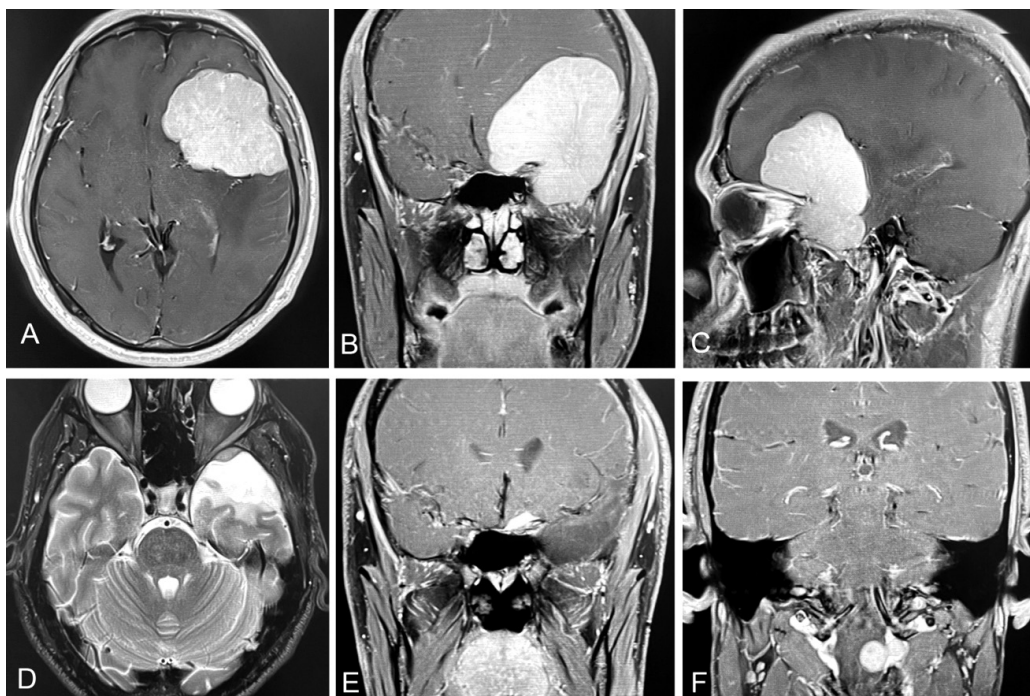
Preoperative axial T1-weighted image (A), coronal (B), sagittal (C) demonstrated a large extra-axial mass with uncal herniation, attached at left orbital roof, left anterior clinoid process and sphenoid wing. noted Postoperative axial T2-weighted image showed residual lesion(D). Postoperative T1-weighted images showed focal residual lesion(E), incidental intra-extradural nodule at left side of C2 level, extended to L2 neural foramen with cord displacement (F).
